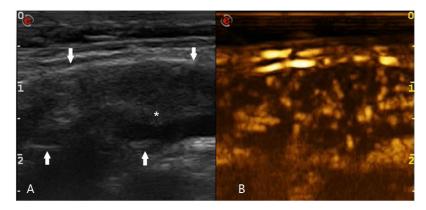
A, A gray-scale ultrasound examination of the suspicious lymph node (*margins outlined with arrows*) showed no signs of malignancy, with the hilum intact (*asterisk*) and no cortical thickening. B, In CEUS imaging, the contrast was equally distributed within the node, confirming the benign nature of the enlargement of the node.
